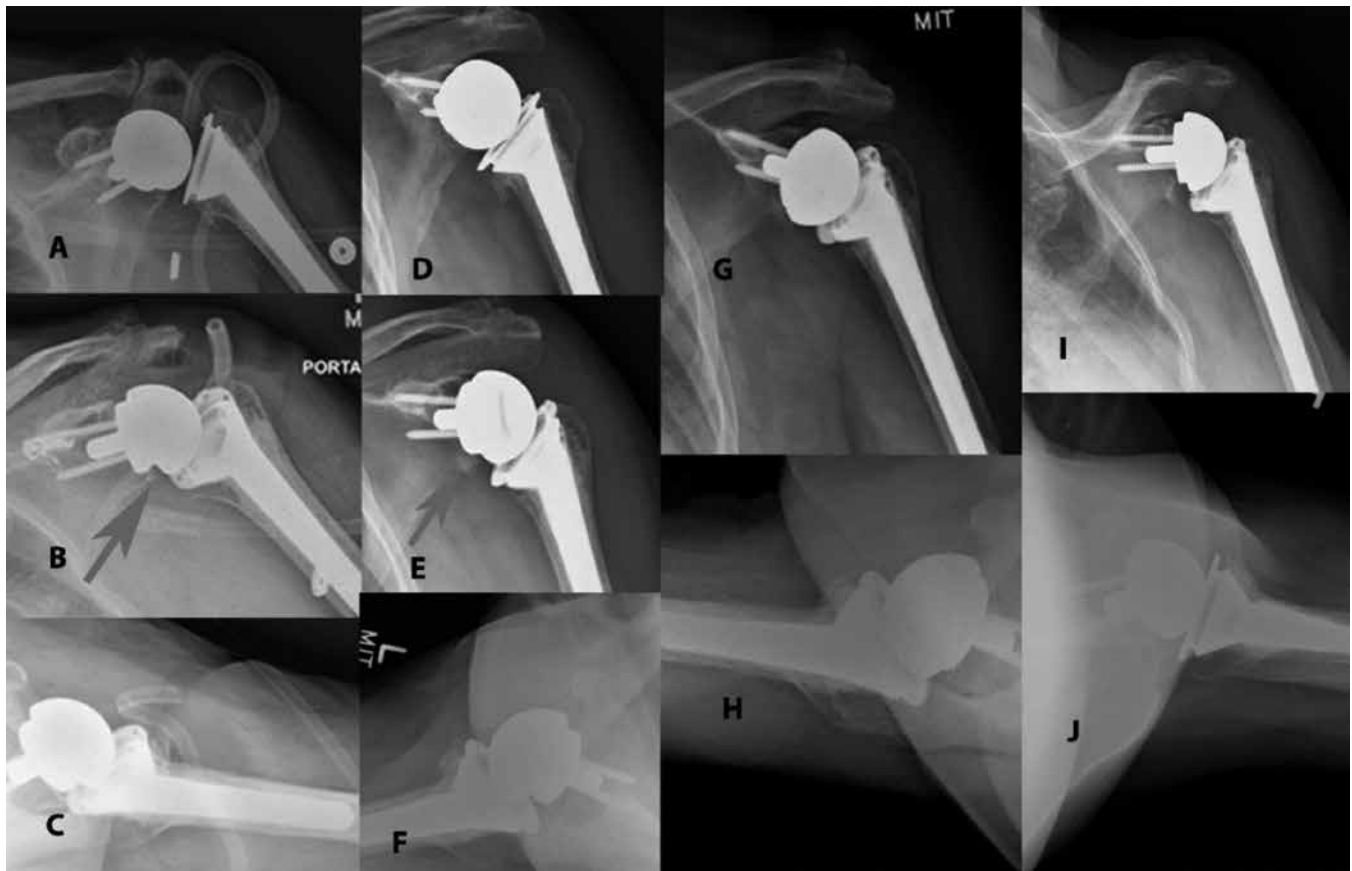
This figure shows the case of a patient with cuff tear arthropathy who underwent RSA for rotator cuff arthropathy. (A–C) X-rays from same-day post-op, (D–F) six-month follow-up films, and (G–H) one-year follow-up films. This progression demonstrates incomplete seating of the glenosphere on immediate post-operative films, followed by spontaneous seating of the glenosphere between six and 12 months. (I–J) 18-month follow-up demonstrating continued seating of the glenosphere. In (A–F), incomplete seating is observed with cephalad tilting of the glenosphere.
